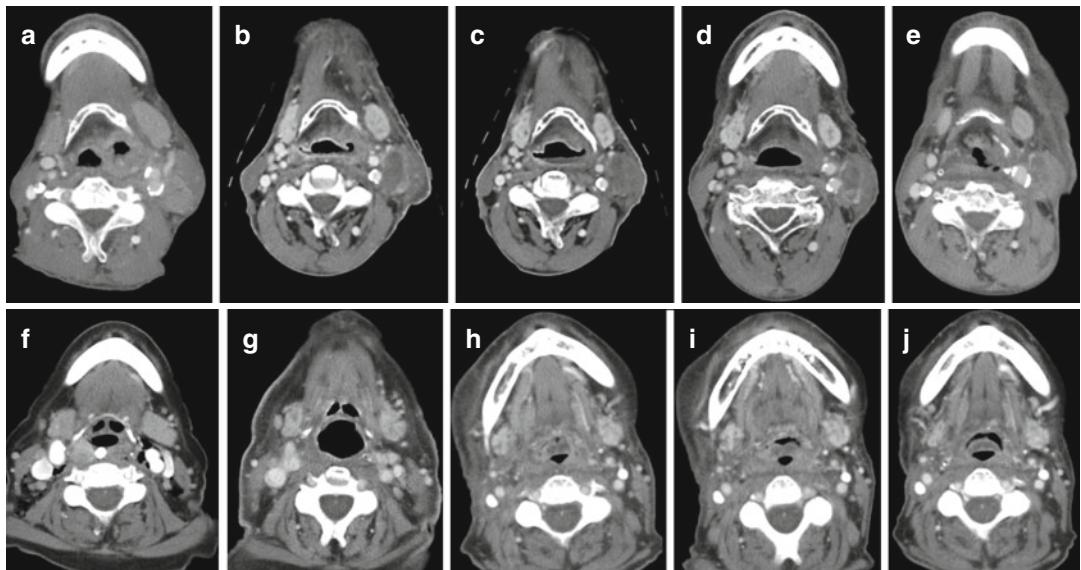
Soft tissue reactions in the short (a–e) and long (f–j) term after intensified radiochemotherapy (target dose 64 Gy; 1. cycle: 2 Gy/d; 2. cycle 2×1.4 Gy/d). Upper row: contrast-enhanced CT in a 63-year-old man treated with RCTx for hypopharyngeal cancer. Normal submandibular glands before therapy (a) and volume reduction and increased contrast enhancement after 48 Gy (b), after 56 Gy (c), 1 month after RCTx (d), and 3.5 months after RCTx (e). Gradual increase of edema in the pharyngeal mucosa, retropharyngeal space, and subcutaneous fat.
